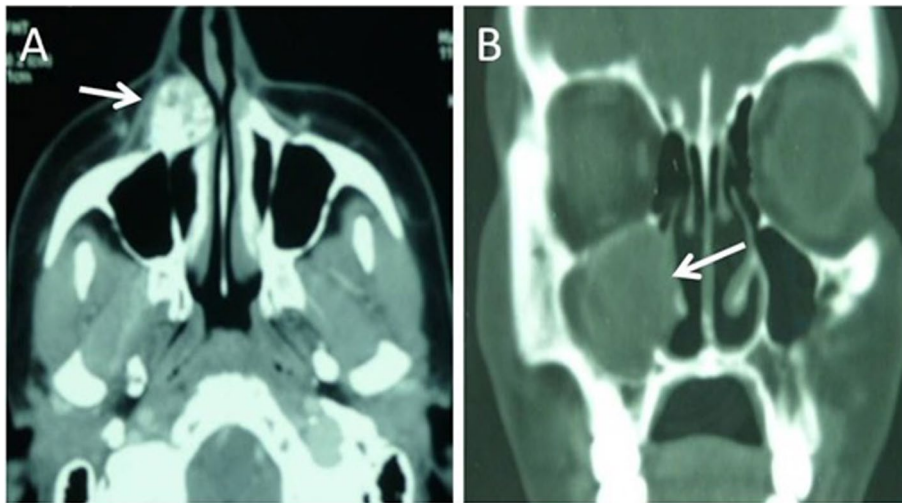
CT scan of lesions enucleated endoscopically via trans-nasal approaches. A Calcifying odontogenic tumor (white arrow) excised via endoscopic endonasal minimal rhinotomy. B Right periapical maxillary intra-sinus cyst with scalloping of the maxillary sinus walls (white arrow) enucleated via endoscopic wide middle meatal antrostomy
